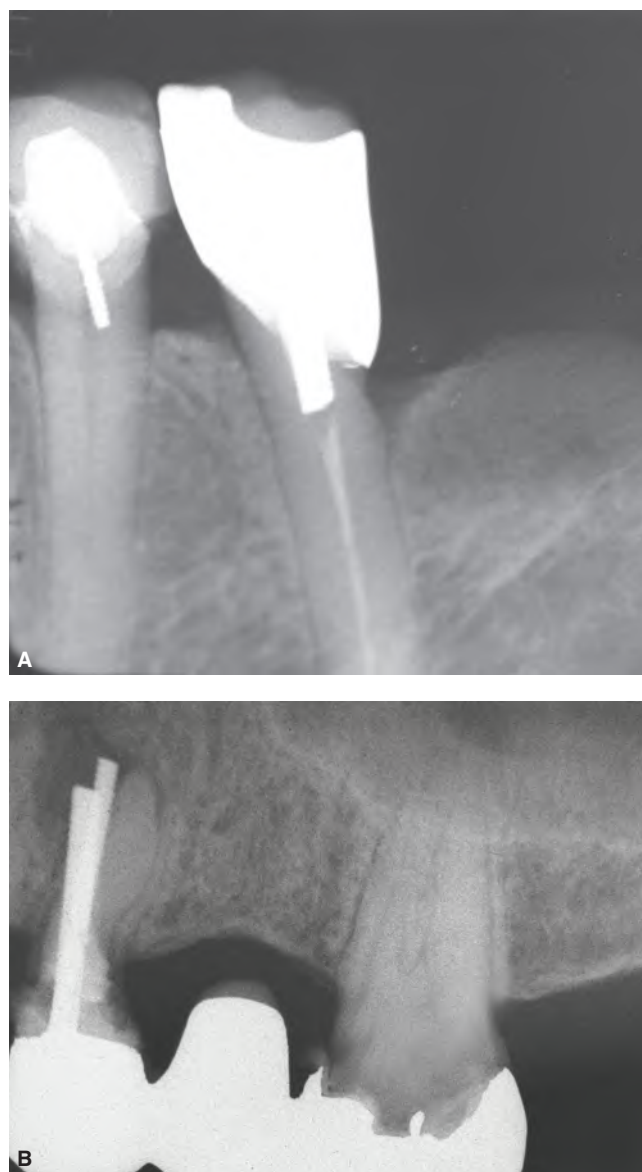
A. Radiograph of a second premolar with a very short post; the lack of adequate retention for the core can result in the prosthesis loosening. B. Radiograph of first maxillary left premolar with a very long post; the inadequate size of the post caused the perforation of the roots. (Figure 9B reprinted with permission from Baba NZ.³³¹)
